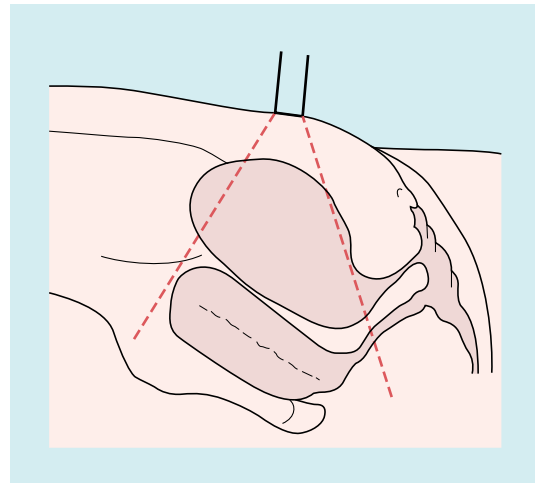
Sagittal planes through the abdomen demonstrating that with a full urinary bladder the geometry for Doppler assessment of blood flow is suboptimal.
